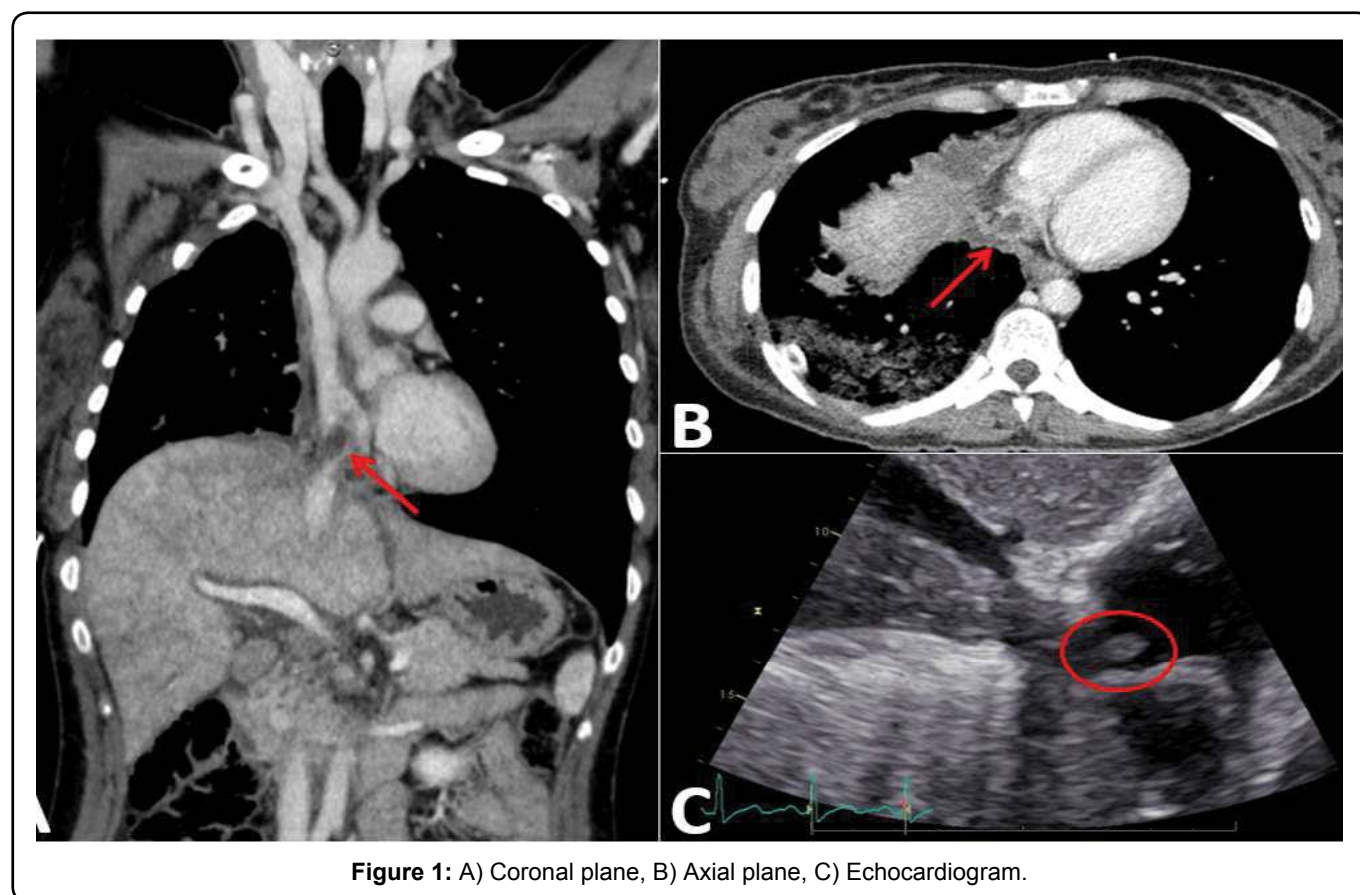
A) Coronal plane, B) Axial plane, C) Echocardiogram.
